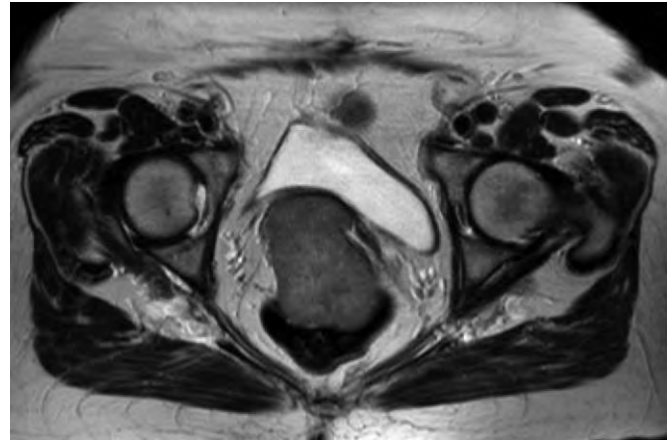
Moderate-sized rectal gastrointestinal stromal tumor on T2-weighted MRI showing homogenous texture and pushing margin.
